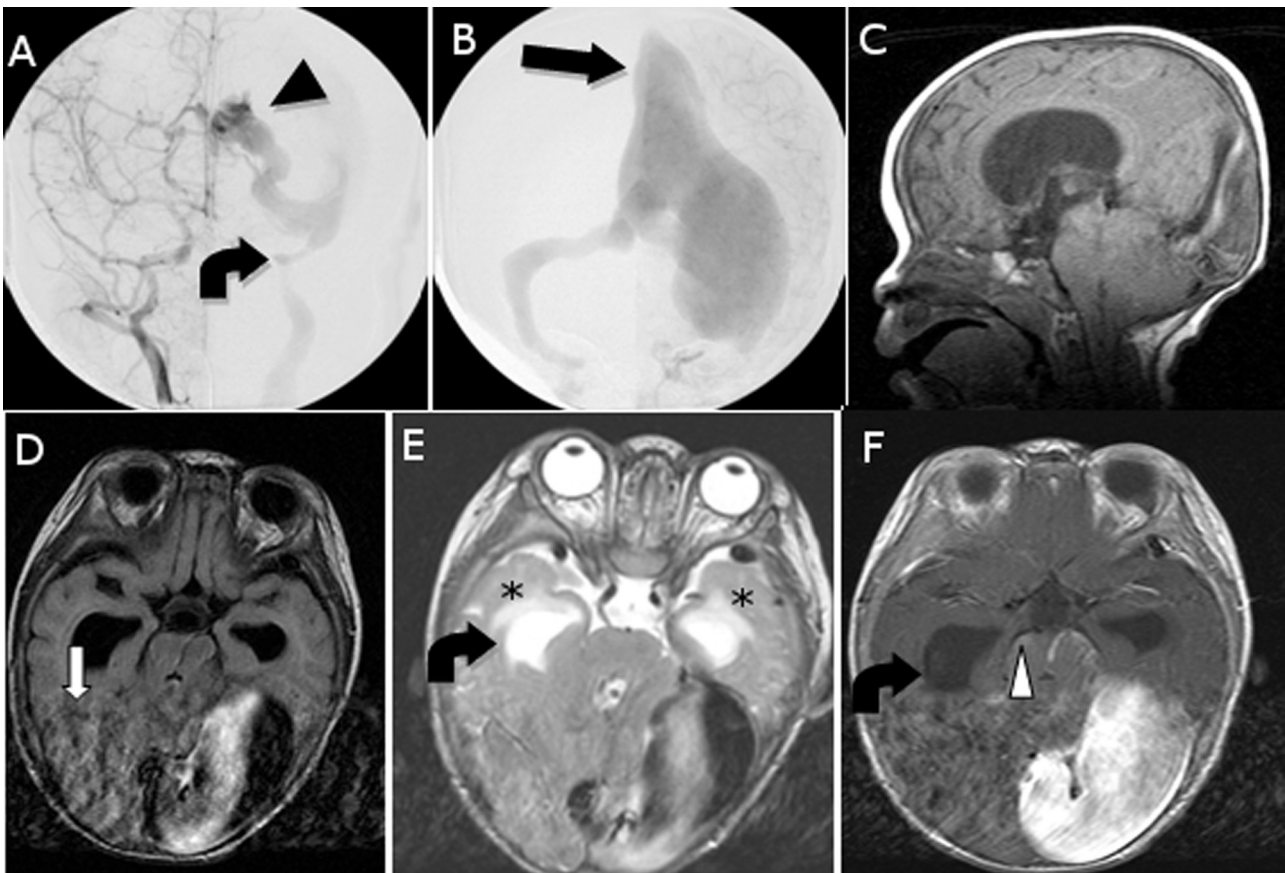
(Case 1): (A, B): Images from an angiogram performed at an outside institution, demonstrating AV shunting from ECA branches into a large recipient venous pouch (arrowhead) secondarily draining into the massively dilated left transverse, sigmoid and distal SSS (arrow). A focal stenosis of the sigmoid sinus at the junction of the internal jugular vein is also observable (curved arrow). (C–F): MRI brain T1W sagittal (C), T1W axial (D), T2W axial (E), and axial T1 post-gadolinium (F) images demonstrate mass effect and downward displacement of the cerebellar tonsils as a consequence of venous hypertension. Significant phase (pulsation) artifact (D, open arrow) indicates the large amount of flow and pulsation within the dural sinus malformation. Hydrocephalus (curved arrows) and transependymal CSF flow (asterisk) is evident as a consequence of venous hypertension. Abnormal dilation of paranchymal veins (venous collateral pathways) of the posterior fossa structures is observable (F, arrowhead).
